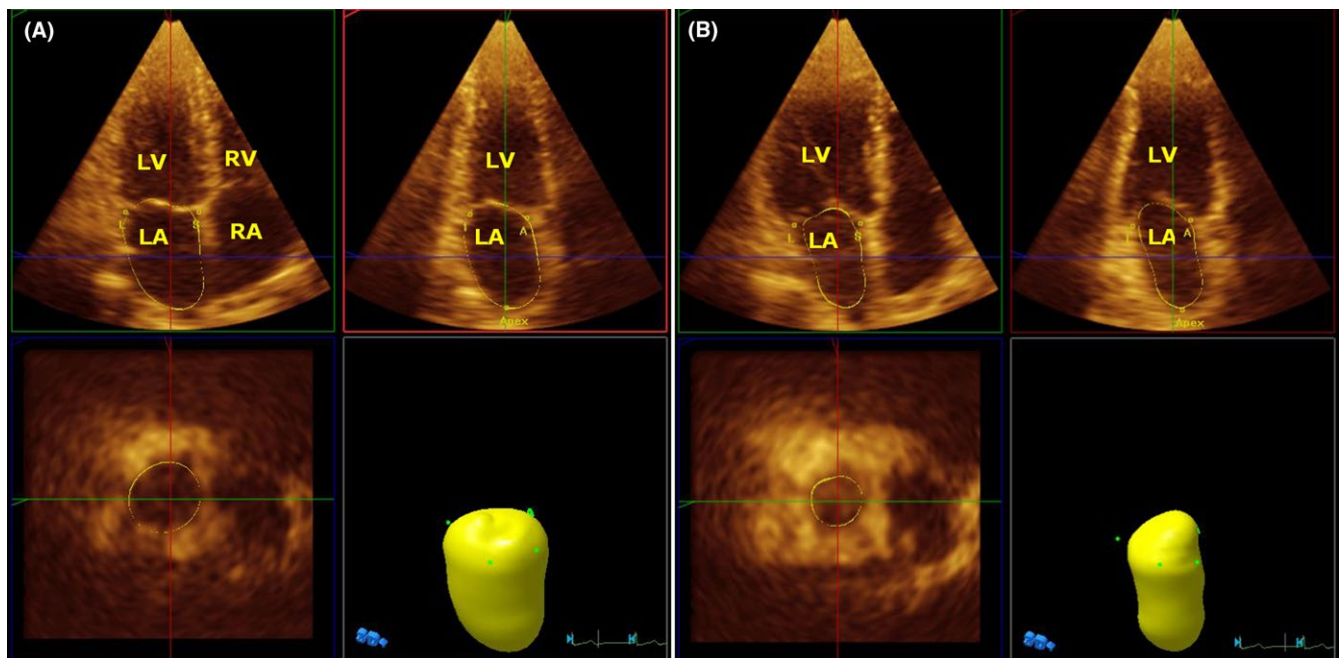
Real time three-dimensional echocardiography recordings of (A) maximum left atrial volume and (B) minimum left atrial volume. LA=left atrium; LV=left ventricle; RA=right atrium; RV=right ventricle
